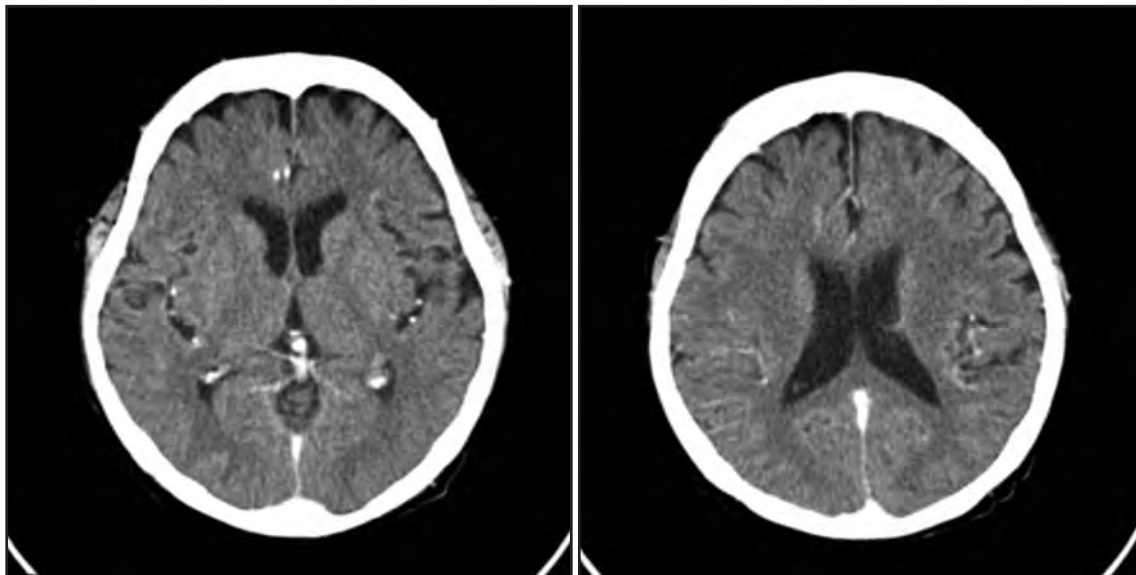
Contrast-enhanced computed tomography of the patient’s brain on day 1 of admission
